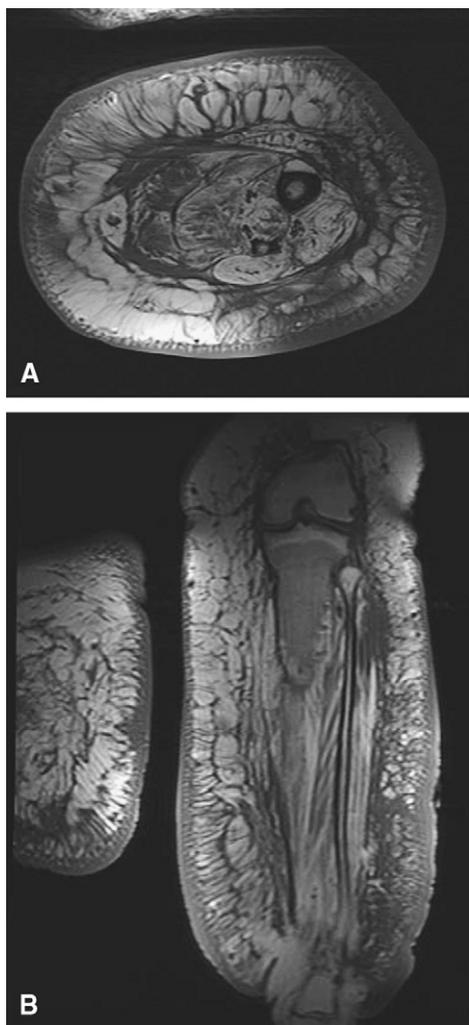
A, Axial and B, coronal T1-weighted lower extremity MRIs show massive circumferential enlargement of the subcutaneous tissue occupied by fat lobules and fibrous septa.
